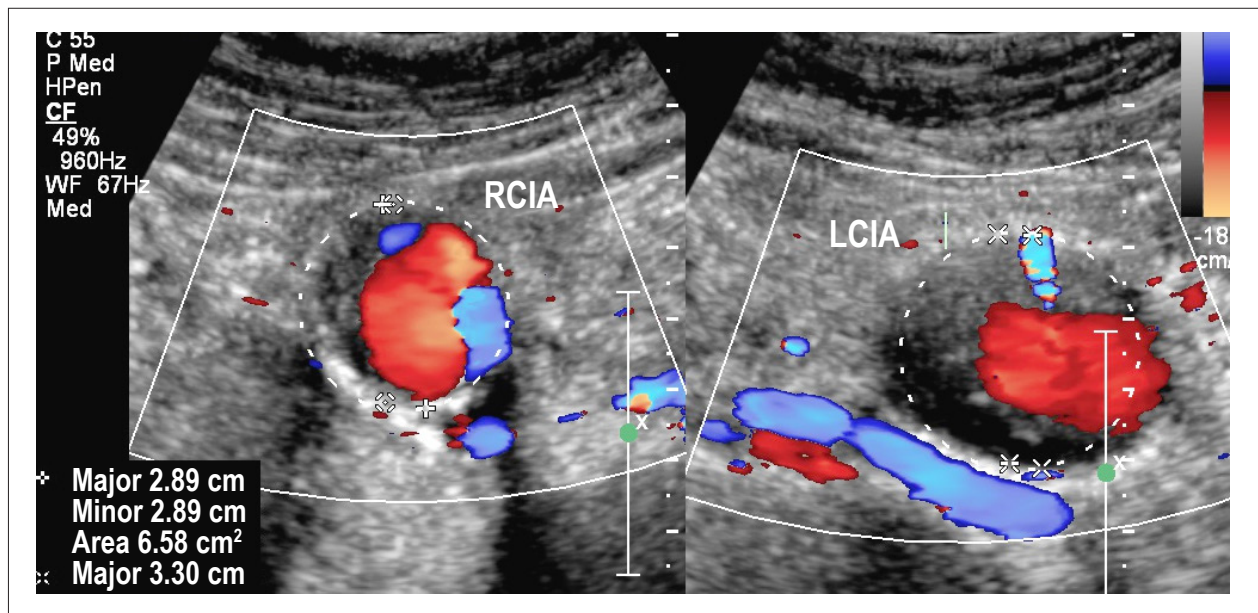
Aneurysm of common bilateral iliac artery. Image in ultrasound section and color mapping: RCIA = 2.89 cm; LCIA = 3.3 cm.
